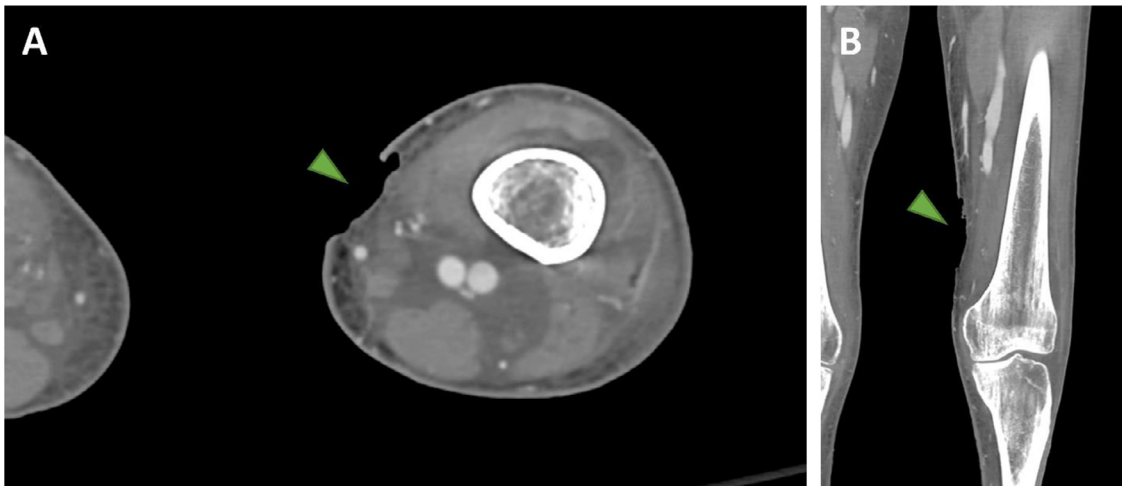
Axial (A) and coronal (B) contrast-enhanced CT of the left lower extremity presented on soft-tissue windows demonstrates a 6.2 cm skin ulceration in the medial distal left thigh (green arrowheads) with adjacent skin thickening and diffuse subcutaneous and soft tissue edema.
